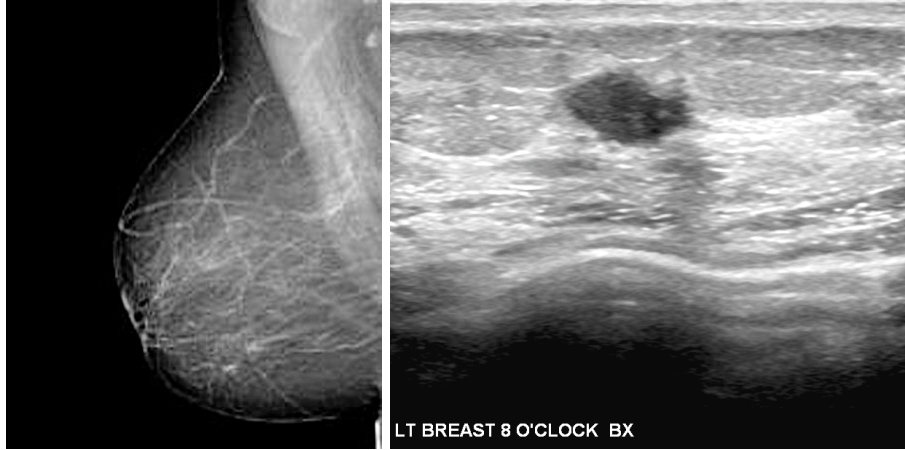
Left:* Digital mammogram revealing micro-calcifications suspicious for ductal carcinoma *in situ* (DCIS). *Right:* The dark, hypo-echoic, irregular shaped mass is DCIS in an image generated by ultrasound.
